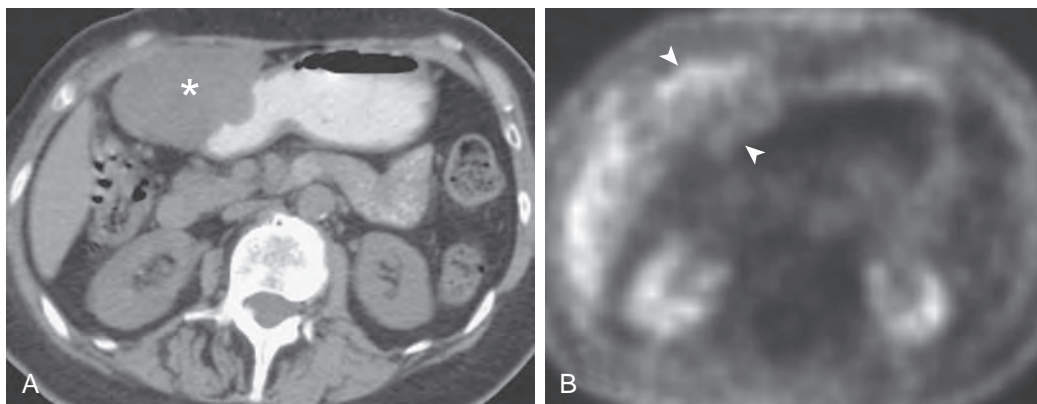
Malignant gastrointestinal stromal tumor with necrosis on CT. A. Non-contrast-enhanced CT scan shows a water-attenuation mass (asterisk) arising from the anterolateral wall of the stomach. B. ¹⁸F-FDG-PET/CT image shows increased activity (arrowheads) in the periphery of the mass. Viable tissue is typically located in the periphery of malignant GISTs that are highly necrotic.
